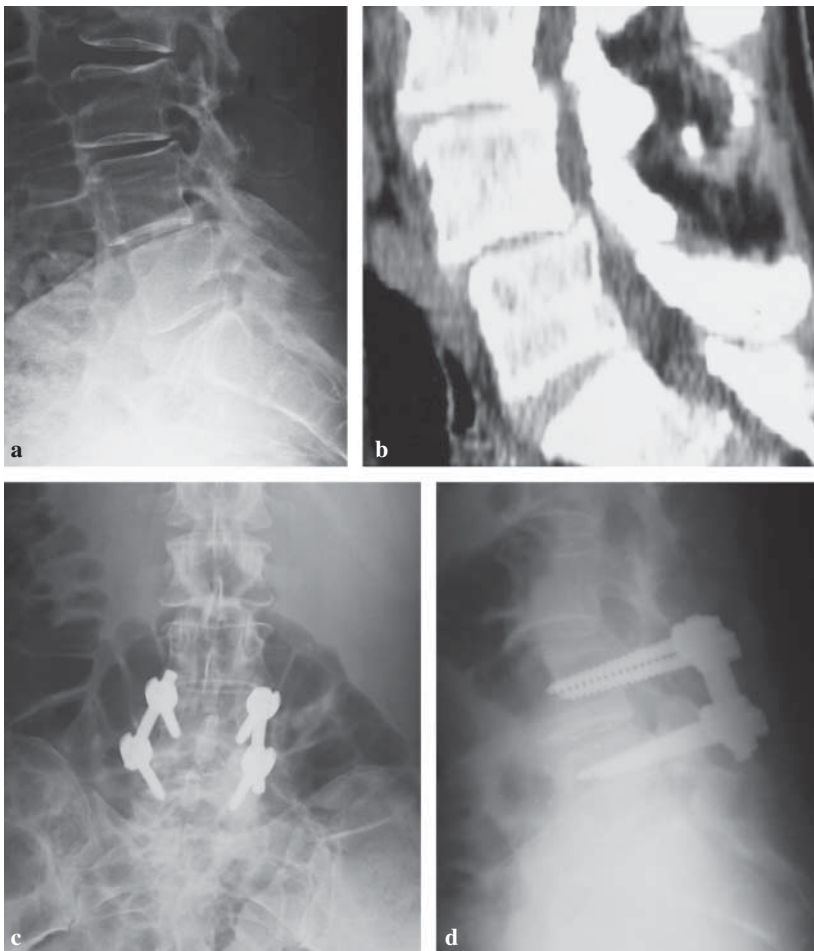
A 64-year-old woman with degenerative spondylolisthesis. a Preoperative lateral radiograph showing listhesis of L4 over L5 with the pars interarticularis intact. b Preoperative computed tomogram showing spinal stenosis at the level of spondylolisthesis. c, d Radiographs at the 4-year follow-up demonstrating reduction of the deformity
